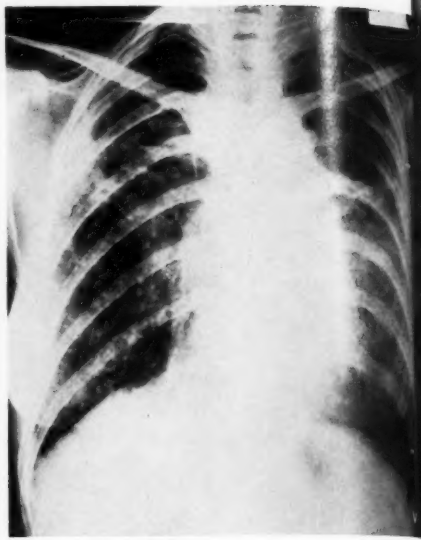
Radiograph showing bilateral apical cavitation and persistent shadowing throughout both lung fields.
